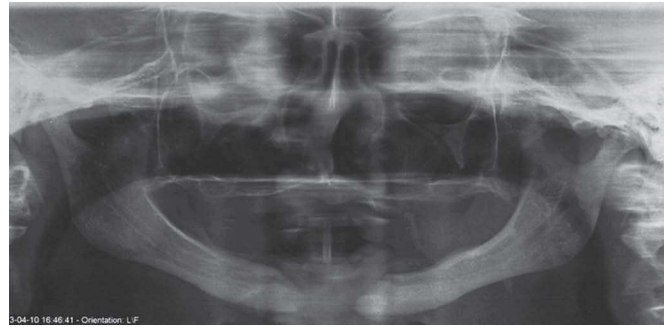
Panoramic radiograph revealing resection of anterior mandible and absence of osteonecrosis symptoms.
